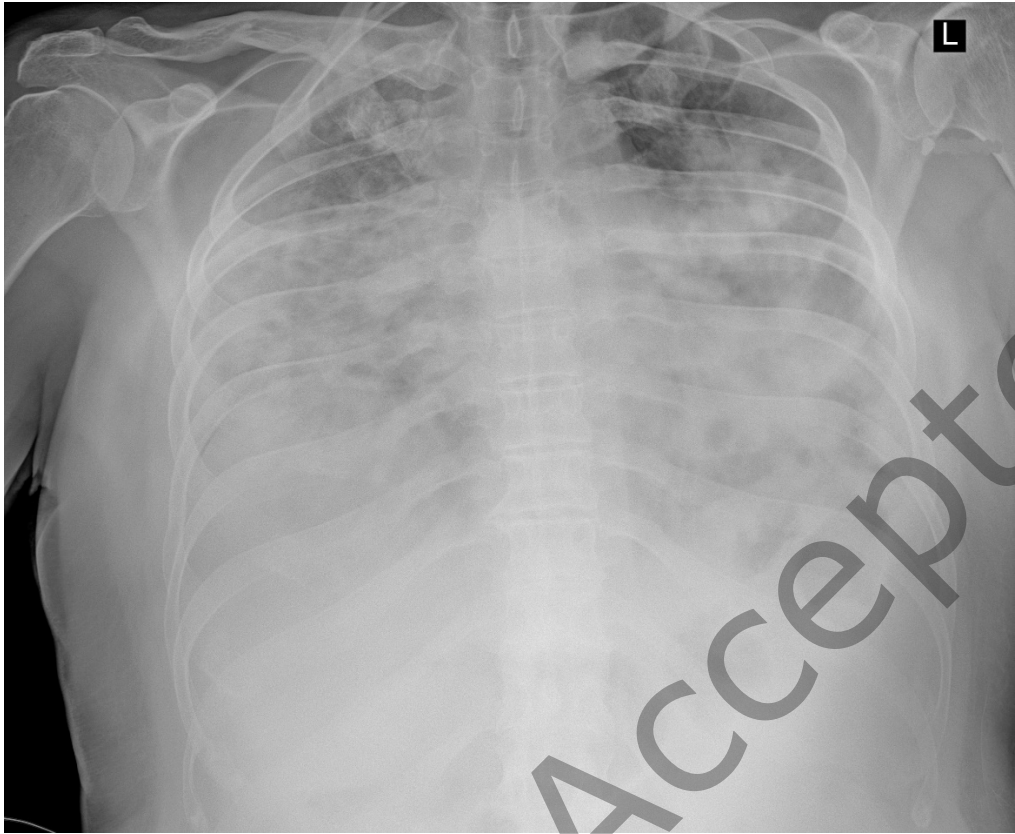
X-ray before tocilizumab therapy
